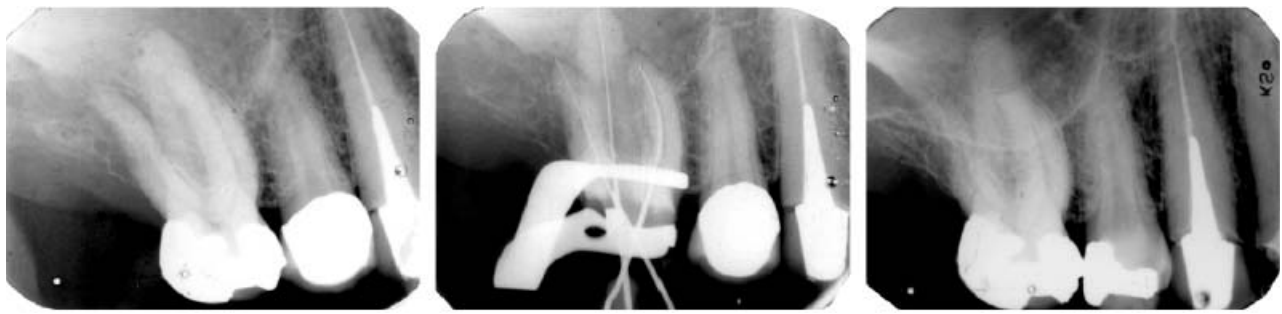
In a patient presenting with pain in the upper right molar region a dentist believed he found the reason for it in a periapical lesion that he saw in the left one of these images and initiated endodontic treatment. A comparison with a previously taken radiograph (right image) might have made him perceive the absence of the lower border of the maxillary sinus and the presence of soft tissue within it indicating a different cause of the patient's problem than an inflammatory periapical lesion. Eventually it was found that the patient suffered from a malignant lymphoma.
